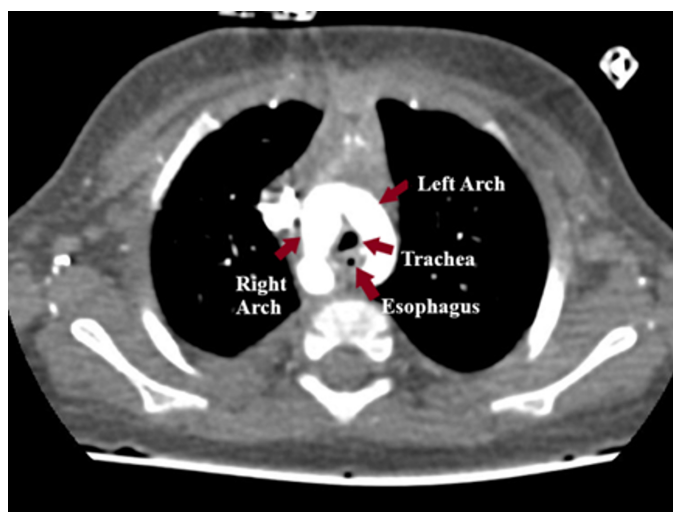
Computed tomography of the thorax showing the vascular ring surrounding the trachea and esophagus.
